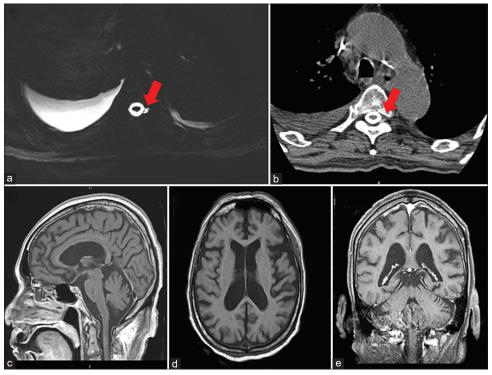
(a) MRI myelography image showed one area of localized fluid collection (red arrow) in the left foraminal epidural space at T4/5. (b) CT myelography showed one area of localized contrast collection in the left foraminal epidural space at T5/6 (red arrow). (c-e) Brain MRI showed no evidence of brain metastasis, pachymeningeal enhancement, subdural fluid collections, and brain sagging. MRI = Magnetic resonance imaging; CT: Computerized tomography
